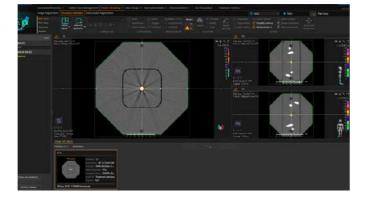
CT dataset of the RUBY with Linac QA insert. The isocenter position is defined based on the 6 CT markers.
